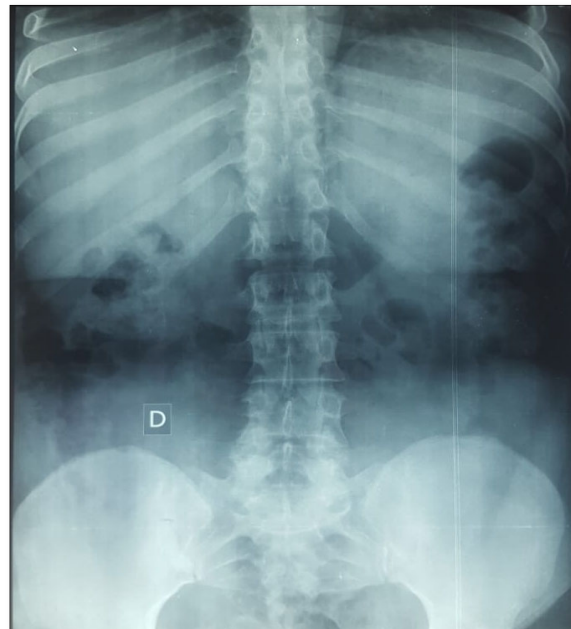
The pelvic X-ray that showed bilateral sacroiliitis, grade 3 in the right sacroiliac joint and grade 4 in the left sacroiliac joint.
